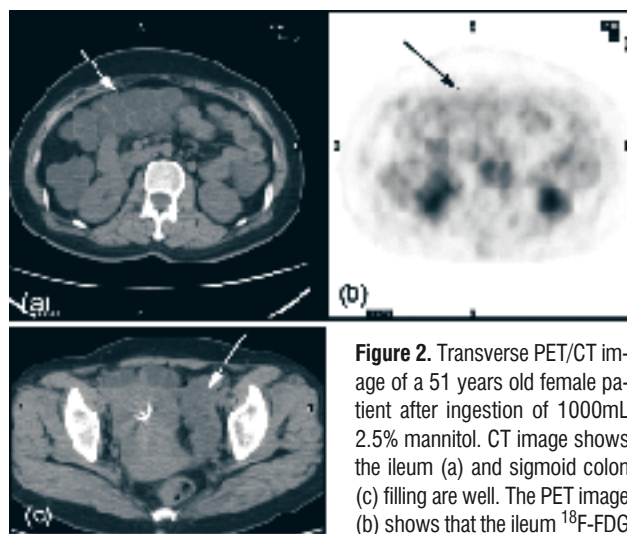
Transverse PET/CT image of a 51 years old female patient after ingestion of 1000mL 2.5% mannitol. CT image shows the ileum (a) and sigmoid colon (c) filling are well. The PET image (b) shows that the ileum ¹⁸F-FDG uptake is relatively less.
